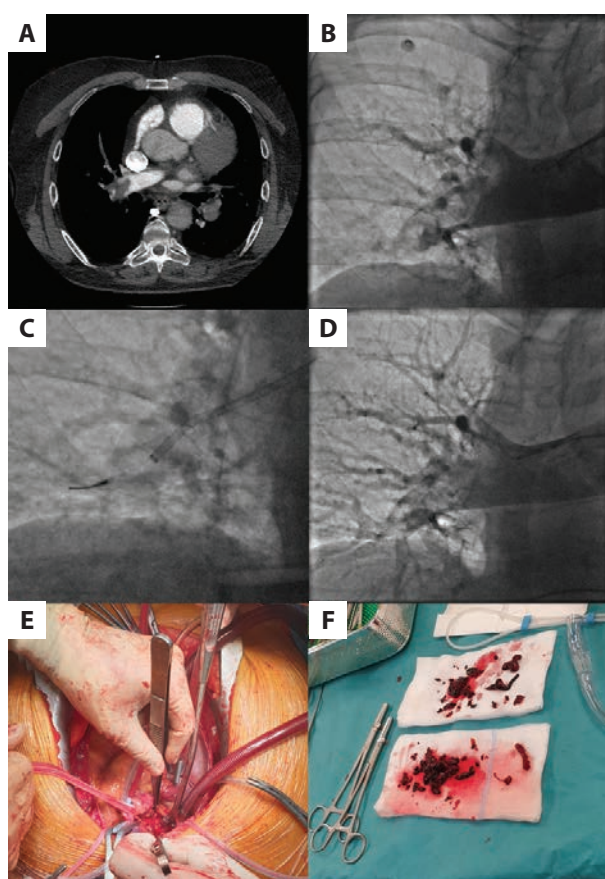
A. Computed tomographic pulmonary angiography. B. Pulmonary angiography prior to thrombectomy. C. Pulmonary thrombectomy — Indigo Aspiration System. D. Pulmonary angiography after thrombectomy. E–F. Surgical embolectomy
